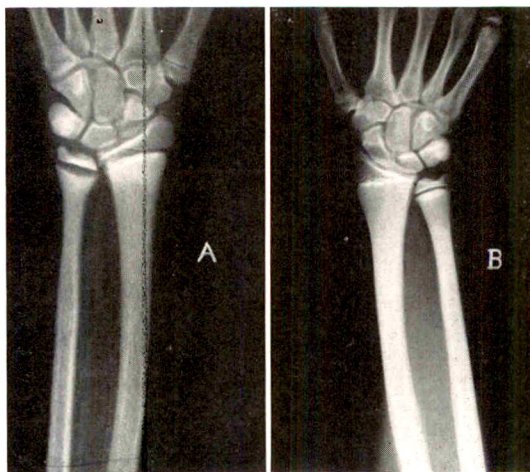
Hyperparathyroidism in a boy aged fifteen. Roentgenogram (A) was made when the serum calcium was 19.4 mg. per 100 c.c. and inorganic phosphorus 4.0 mg. Note the rachitic zone of osteoid at the metaphyses and the generalized osteoporosis. Roentgenogram (B) was made four months after the surgical removal of a large parathyroid adenoma (3×4 cm.) and the serum calcium and inorganic phosphorus had returned to normal levels. The bones are now well ossified. (This case is presented through the courtesy of Dr. M. C. Sosman of the Peter Bent Brigham Hospital.)
